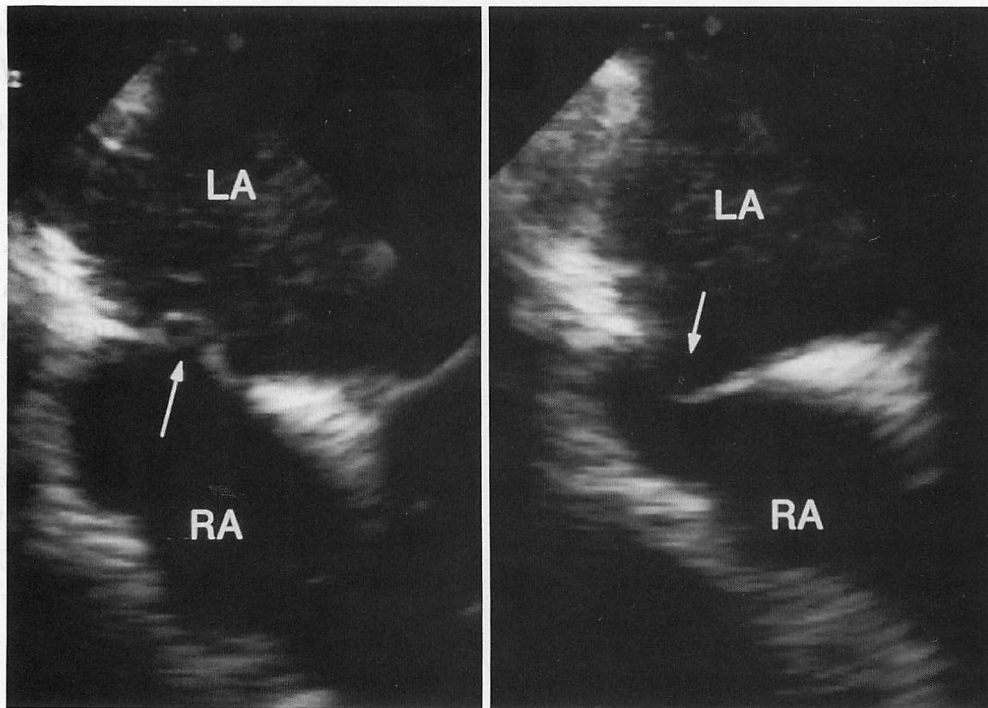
Transesophageal echocardiograms (TEE) showing a redundant atrial septal aneurysm bulging into the left atrium (LA) by 6.3 mm (left) and into the right atrium (RA) by 7.2 mm (right). Spontaneous echo contrast ("swirling") in the left atrium is also seen.
